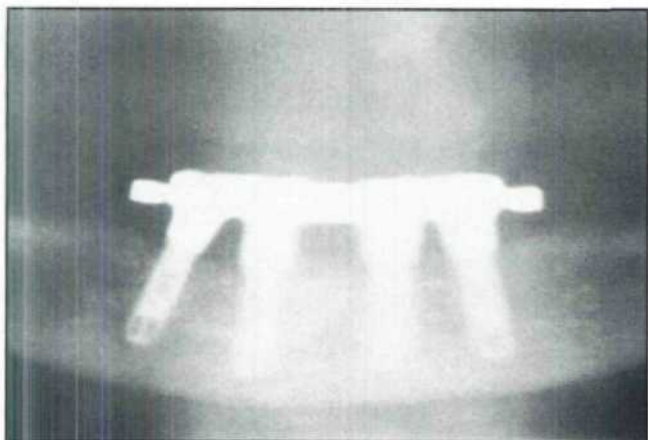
Panoramic radiograph of the definitive restoration, which consisted of 4 implants and a bar overdenture, 6 years following loading.
